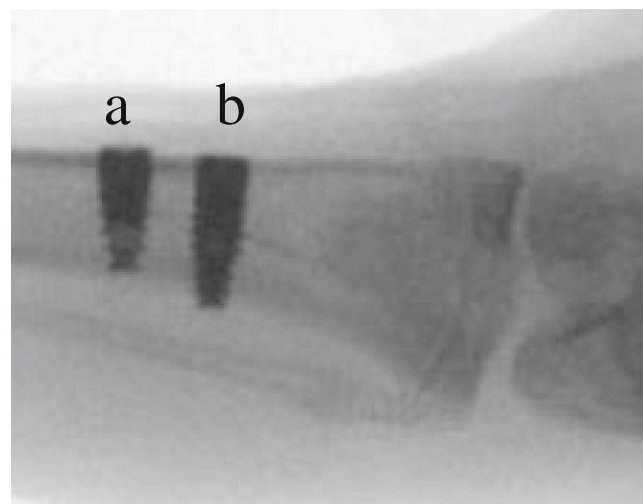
Radiograph confirming the position of the implants in relation to the cortical bones. a SPI® implant inserted with an under-drilling protocol (UD). b ICE® implant inserted with an over-drilling protocol (OD)
